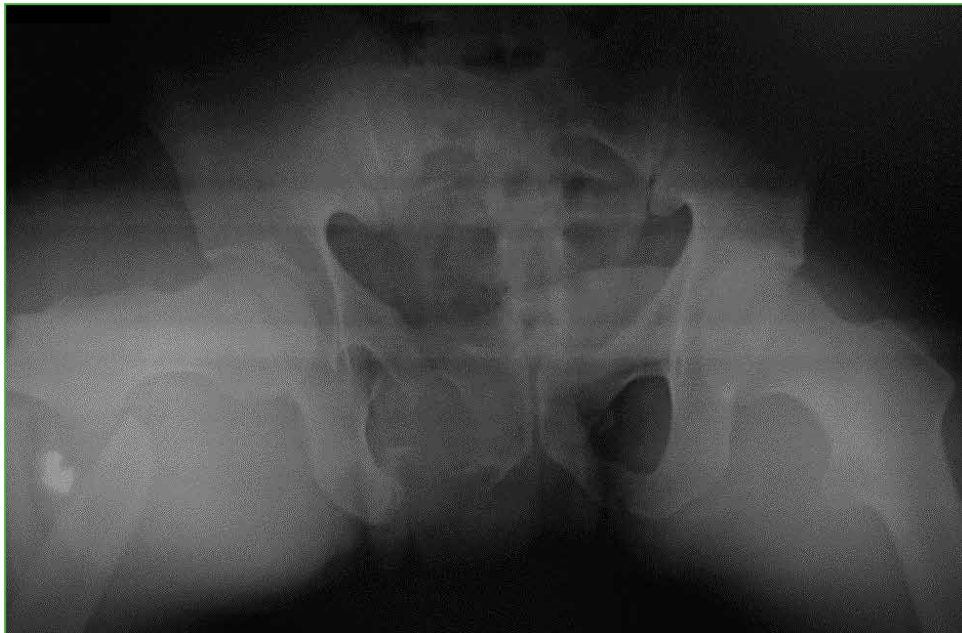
Anteroposterior pelvic radiograph. A pelvic fracture associated with an ipsilateral femur fracture (floating hip) is observed.
